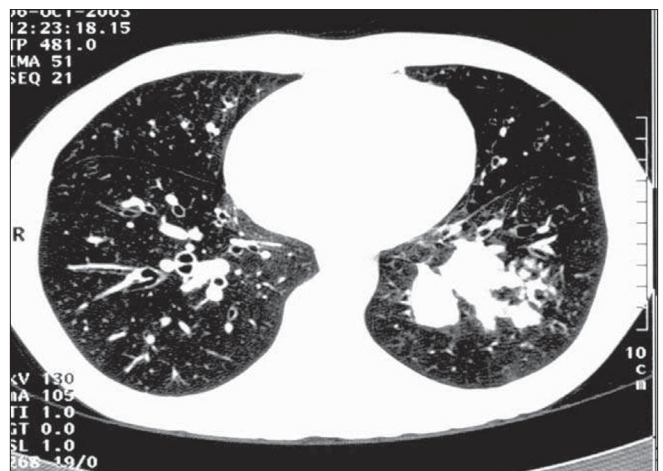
CT chest – lung windows
